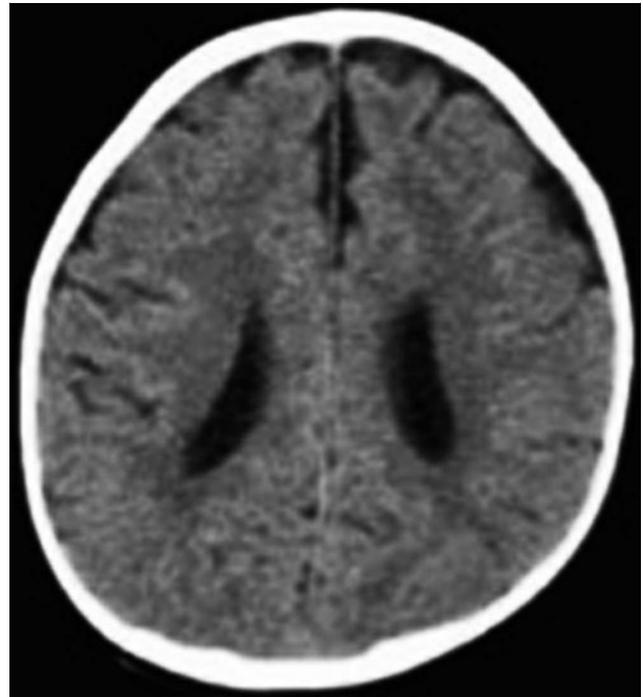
Axial nonfused computed tomographic (CT) scan of the head of a 6-month-old boy with occipital plagiocephaly. CT scan demonstrates enlarged subarachnoid spaces, which are reported to be associated with positional plagiocephaly.
